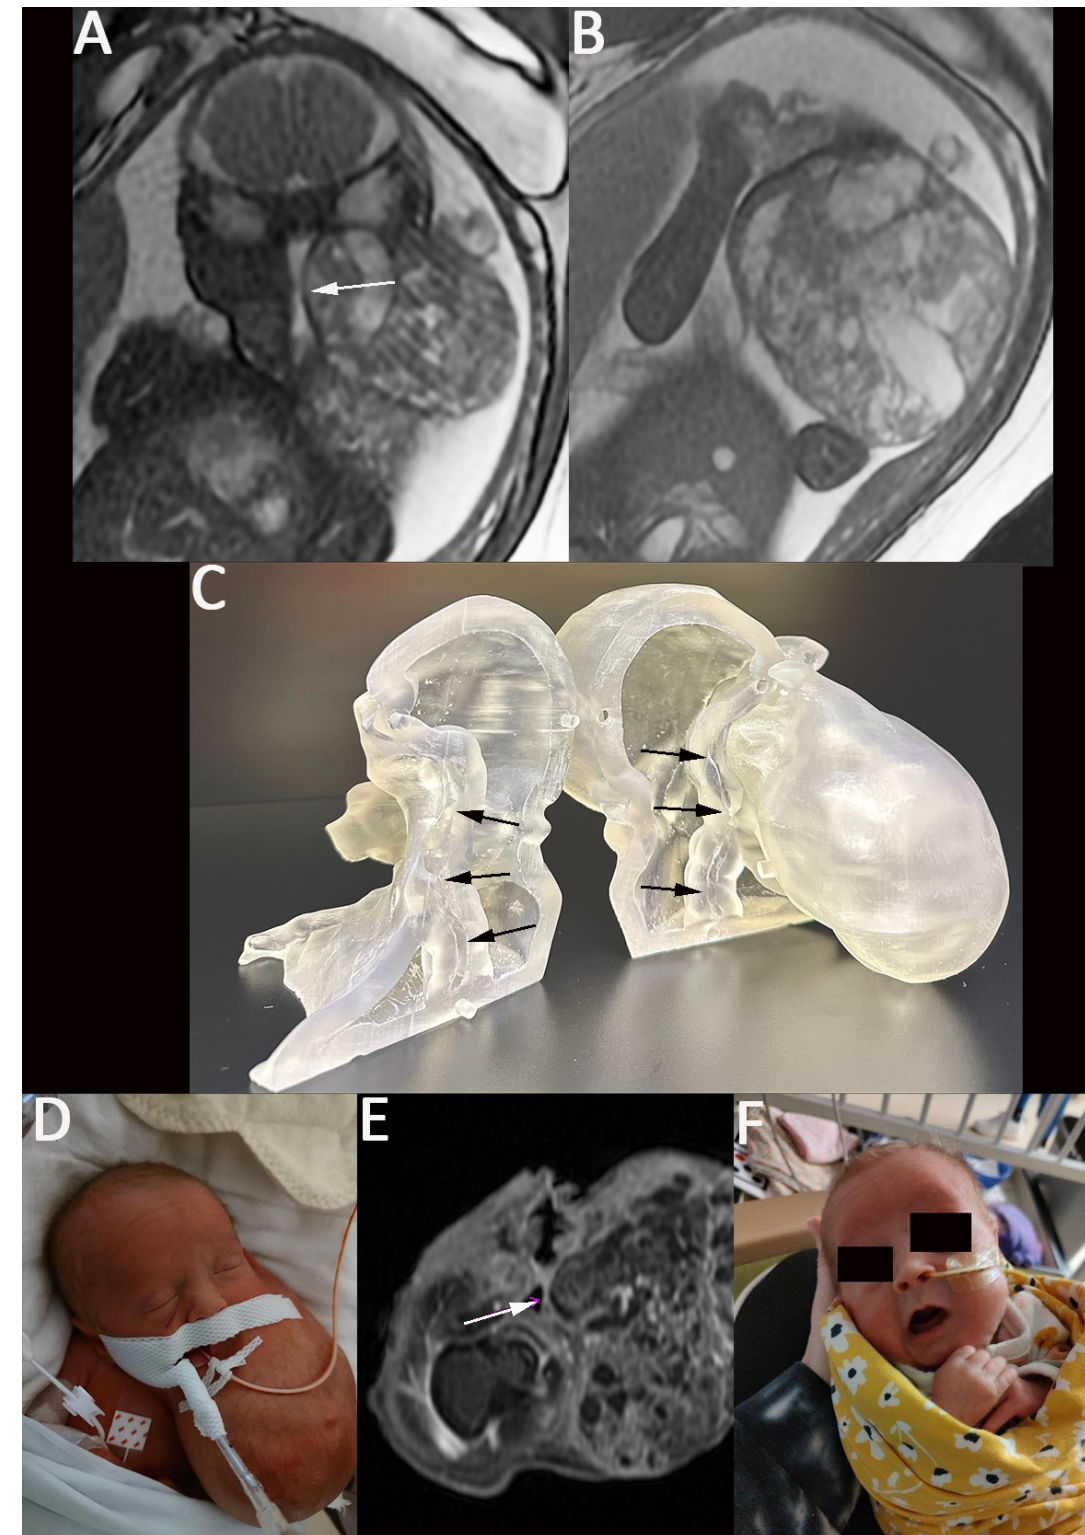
Fetal MRI T2-weighted single-shot fast-spin echo coronal (A) and axial (B) show large fetal cervical mixed solid and cystic mass, closely approximating or involving the left pharynx wall with airway narrowing (arrow, A). 3D print (C), fabricated as an assembly, shows the removable bulk of the mass, as well as internal structures allowing clear visualization of the narrowed airway (black arrows). Postnatal delivery photo of infant (D) shows proportion of teratoma to the infant's head. Postnatal MRI T1-weighted post-contrast axial image (E) redemonstrates the tumor adjacent to pharynx (arrow). Postsurgical image of the infant one week postoperatively (F) shows minimal distortion of left cheek and neck.
